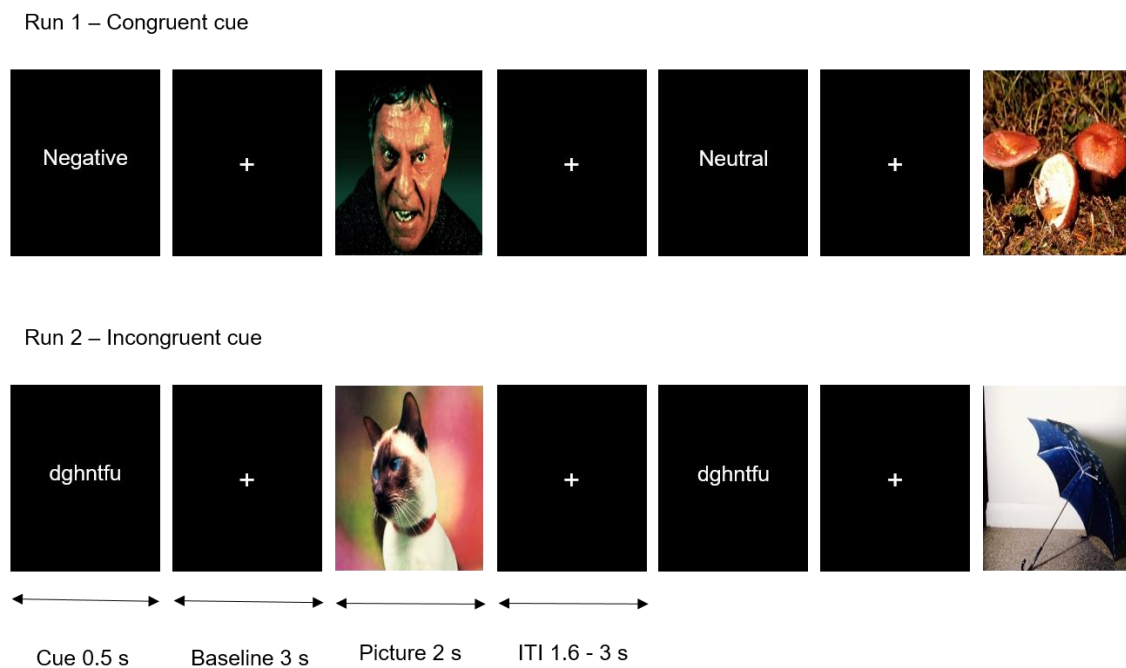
Part of the stimulus sequence presented to the participants inside the magnetic resonance imaging scanner (2 blocks). Negative, neutral, and positive pictures from the International Affective Picture System database were randomly presented. ITI = Interstimulus intervals.
